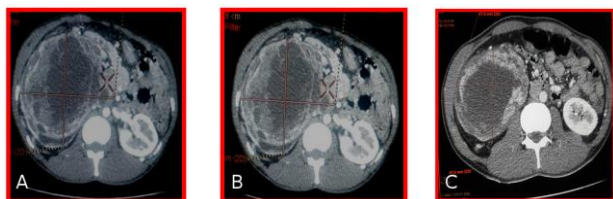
Abdominal CT Scan in axial plane showed the tumour extent (2A) before RAE performed, (2B) after 1st RAE performed, (C) after 2nd RAE performed, it shows that a tumour gradually decreased in size according to axial view
